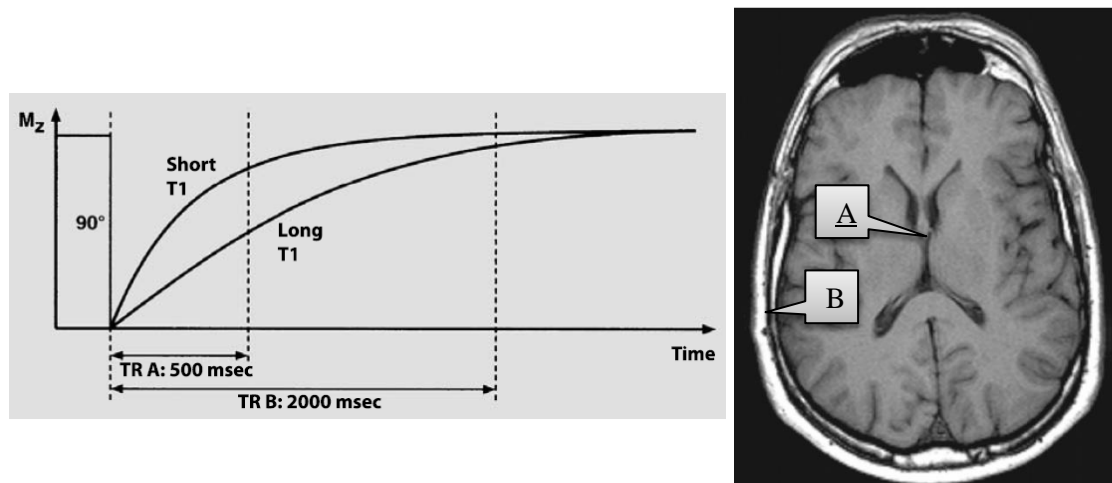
T1 contrast. Left panel: Tissues with short T1 relaxation time (fat) recovers faster than those with longer one (CSF) (adapted from (Koechli et al., 2006)). Right panel: T1-weighted spin echo image through the brain. It shows the dark CSF (A) and bright fat (B) (adapted from (Westbrook et al., 2011)).
